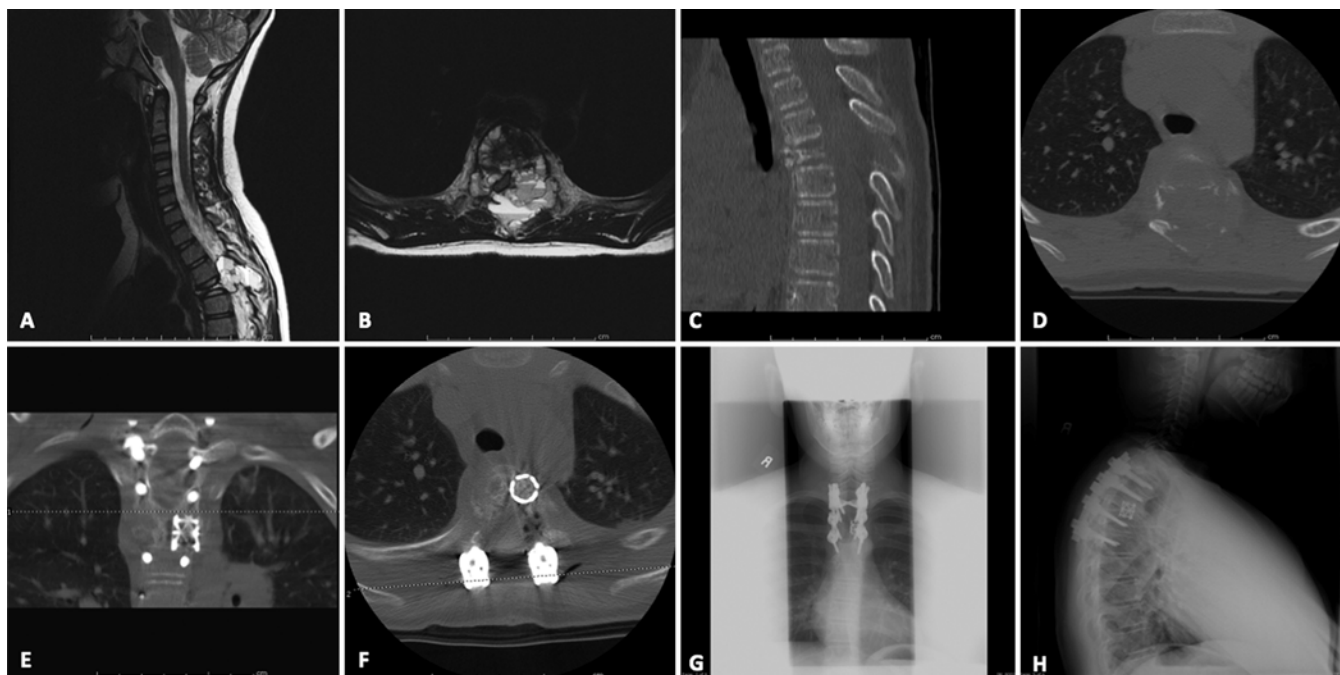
Case 1. Images obtained in a patient with T-4 vertebra plana involvement. Sagittal (A) and axial (B) T2-weighted MR images demonstrating extensive involvement of the fourth thoracic vertebra. Sagittal (C) and axial (D) CT reconstructions showing profound attenuation of the bone and complete collapse of T-4. A coronal CT reconstruction (E) and axial CT scan (F) were obtained after a posterior T2–6 instrumented fusion using cancellous bone graft and a Danek titanium cage. Anteroposterior (G) and lateral (H) plain radiographs of the cervicothoracic spine obtained 5 years after resection showing intact instrumentation.
